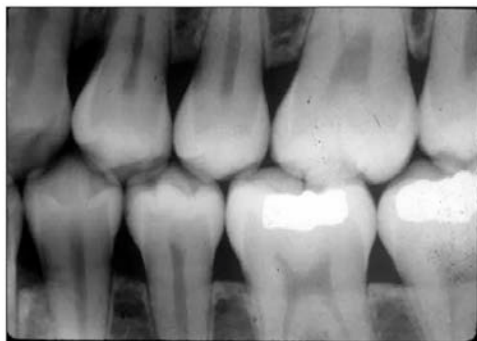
Bitewing radiograph displaying enamel, dentin, and pulp structures.
